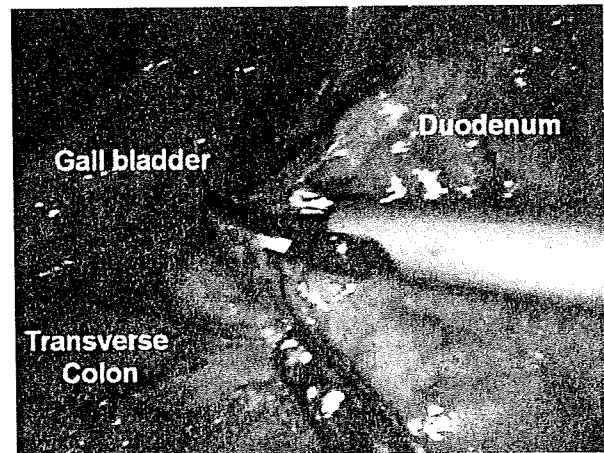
Blood vessels in the area around the tumor margin were occluded using an ultrasonically activated sealed device (Harmonic Scalpel Ace). Adhesions between the gallbladder and transverse colon were sharply dissected, and the bulb and the second portion of the duodenum were exposed
